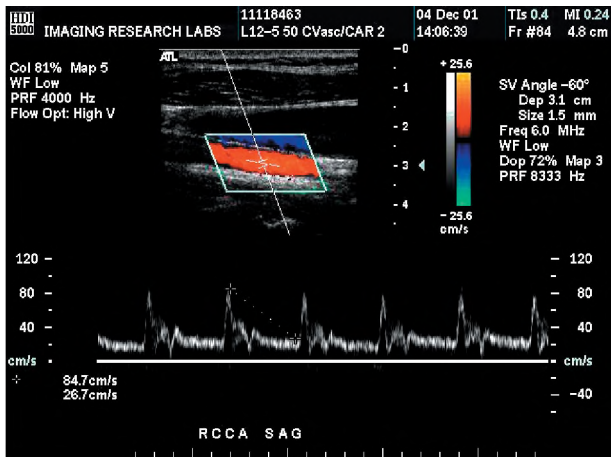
Example from a clinical ultrasound examination showing a B-mode (top centre) image with overlaid colour-encoded map of mean velocity (colour Doppler, shown in central box), along with a DUS spectrogram (bottom) of a sub-volume of velocities as a function of time over 5 cardiac cycles. The DUS sample volume is indicated by the crosshairs at the centre of the B-mode and colour-Doppler image.
